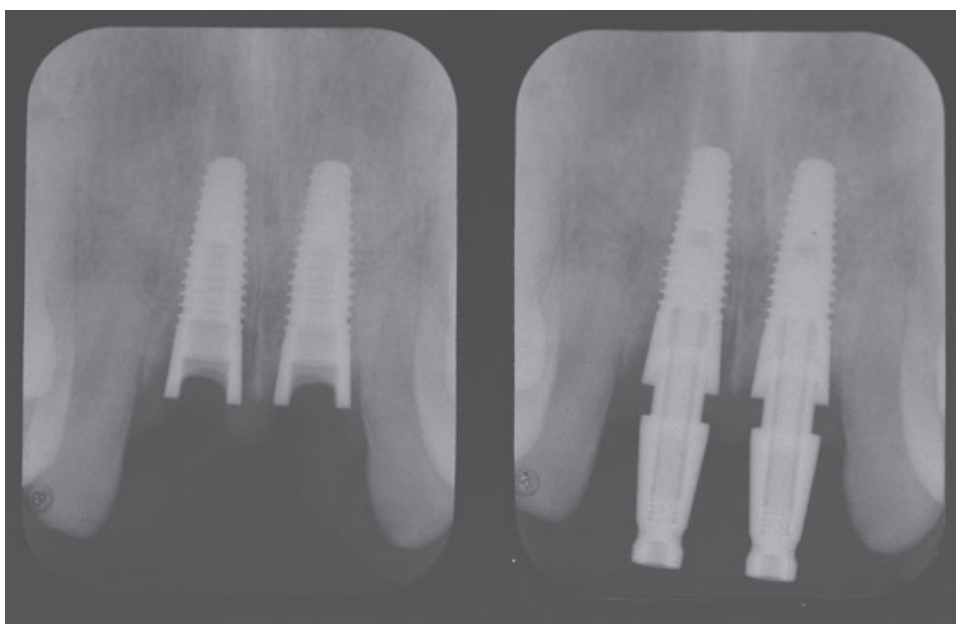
Radiographic views on the day of placement. Interproximal bone peaks are evident between implants.
